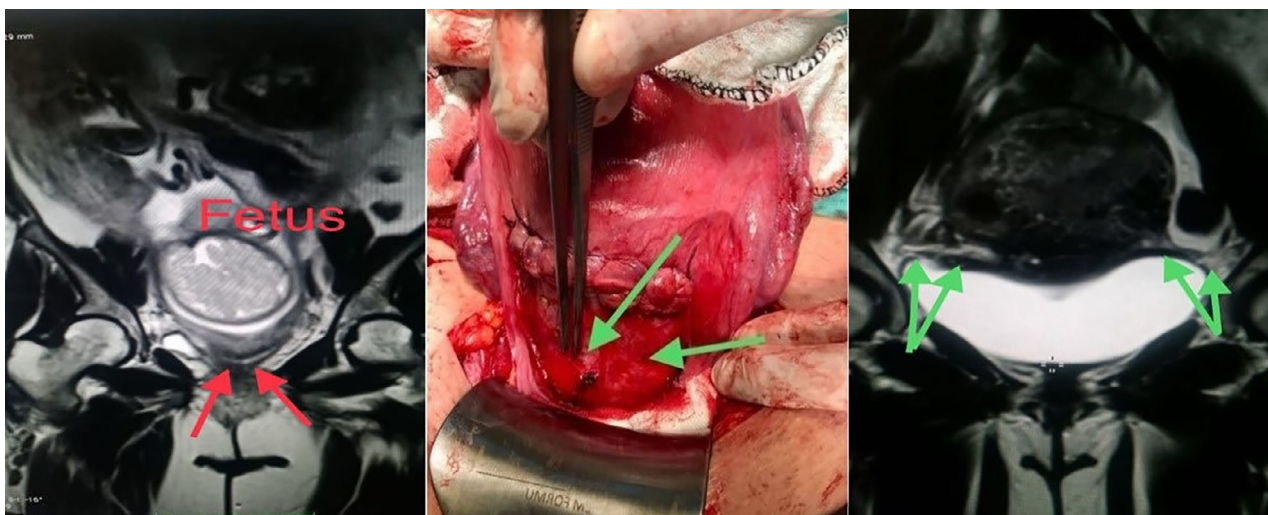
Prepartum magnetic resonance imaging (MRI), intraoperative (caesarean section) view and postpartum MRI show relation of mesh, uterus and pectineal ligament respectively.
